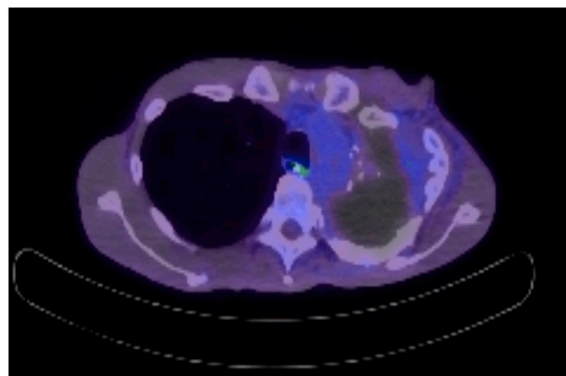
PET/CT view of the fibrotic, necrotic residual change with no evidence of FDG uptake several years following treatment.
